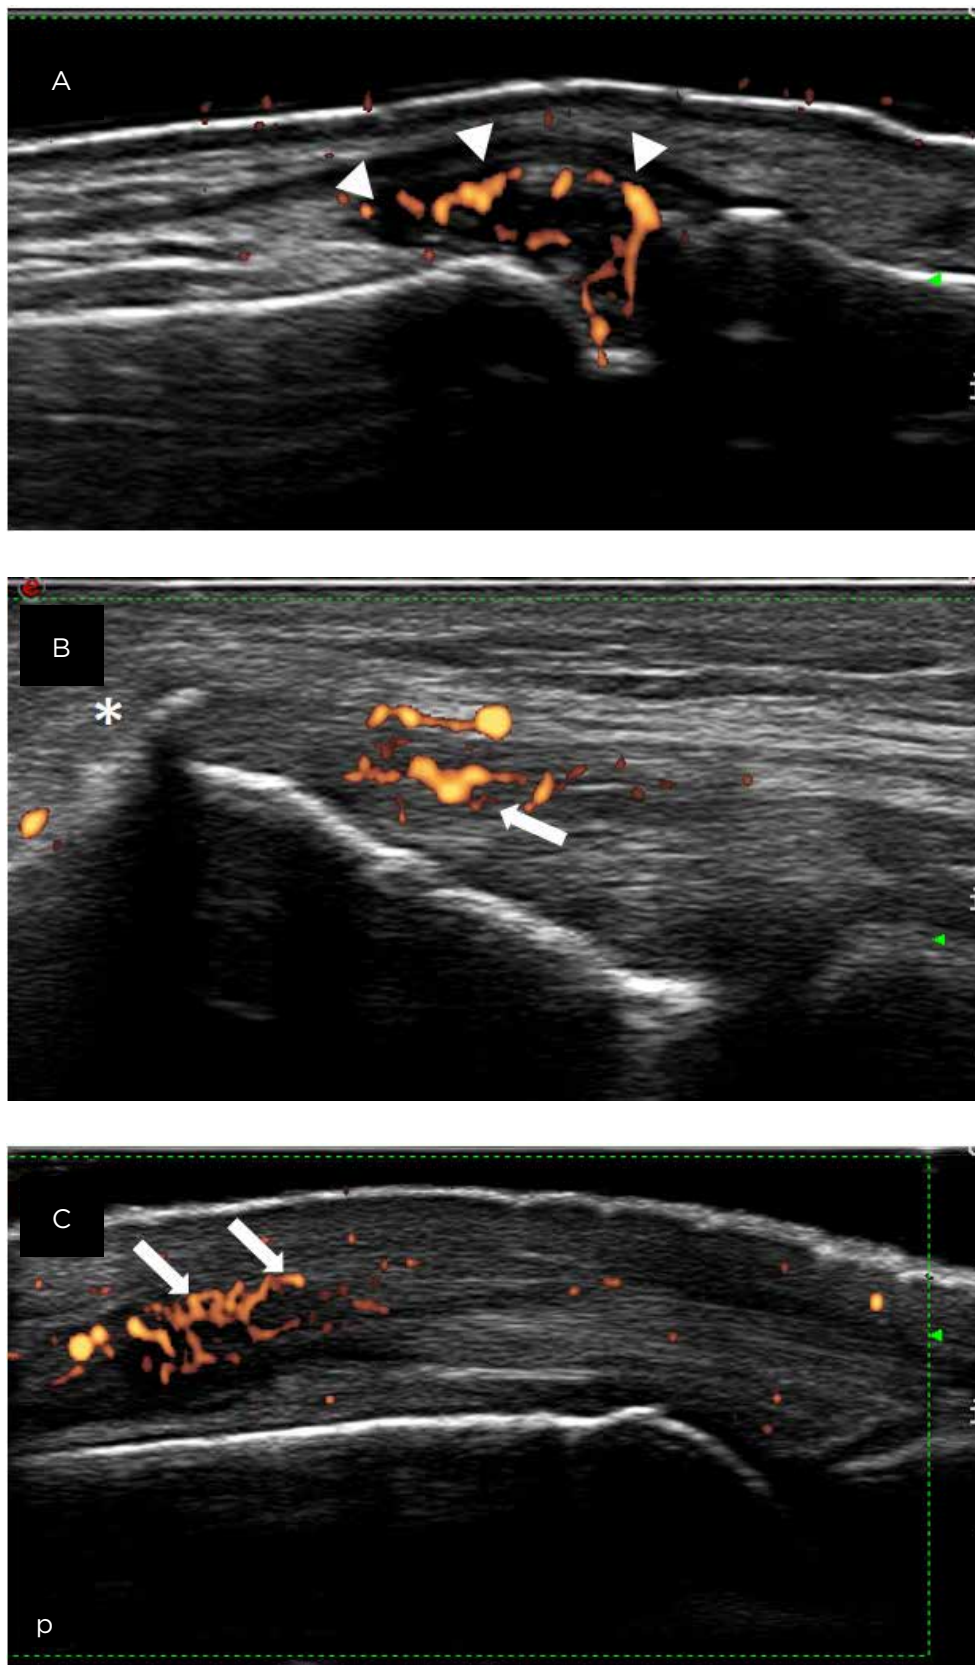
Examples of ultrasound findings in psoriasis arthritis (PsA).
